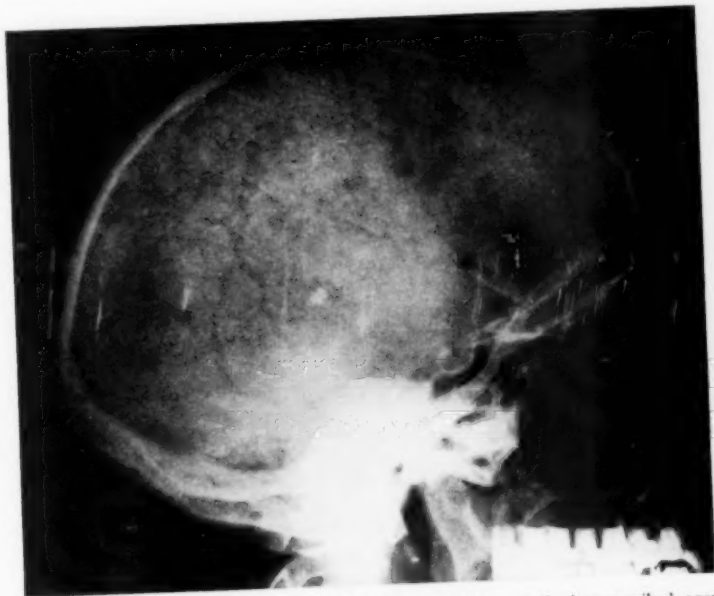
Case 5. Roentgenogram of the skull demonstrating small circumscribed areas of radiolucence associated with thickening and granularity of the vault.
